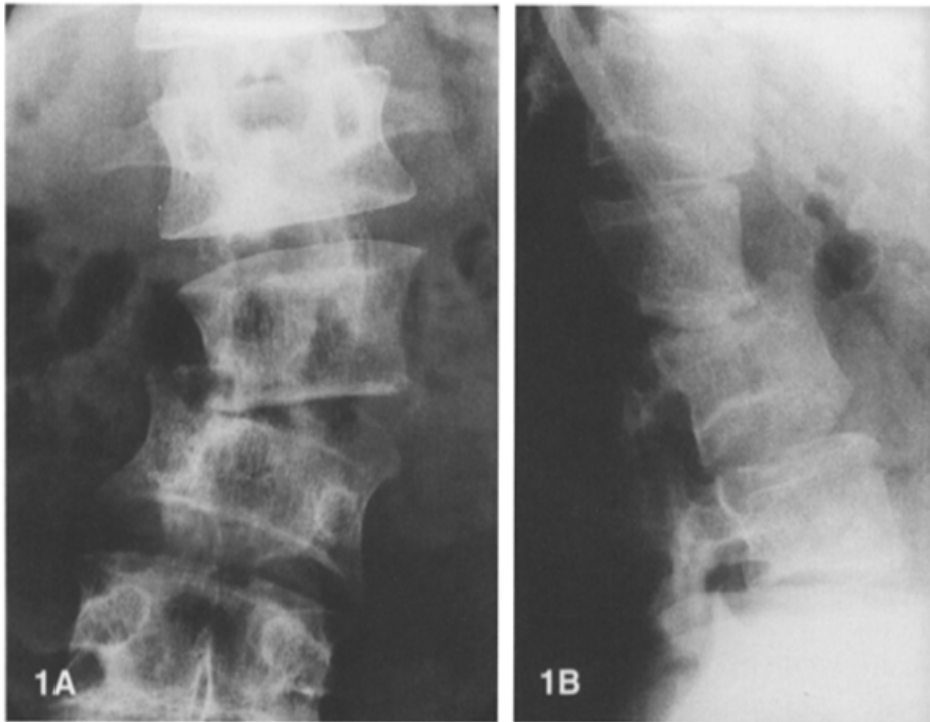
A. Plain radiograph showing absence of the pedicles of L2 and scoliosis.
